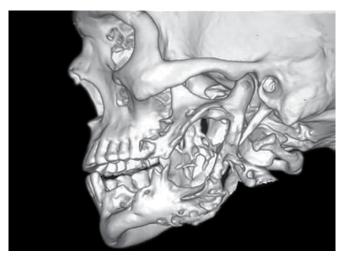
3D CT scan lateral view
